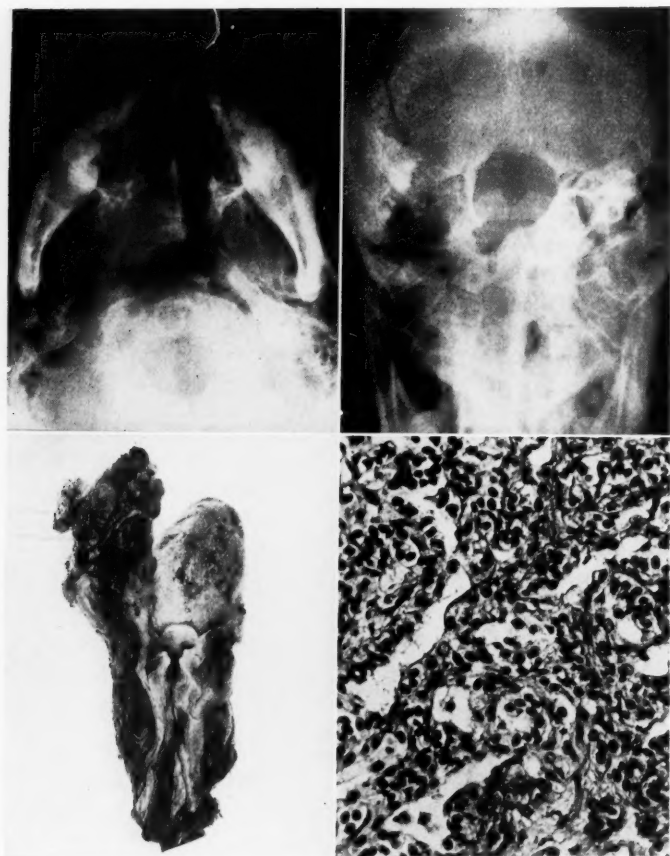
Roentgenograms and pathological material from a patient dying with an advanced transitional cell carcinoma of the pharynx which had extended through the floor of the middle fossa on the affected side, destroyed the inner petrous portion of the temporal bone and protruded through the external auditory canal.
